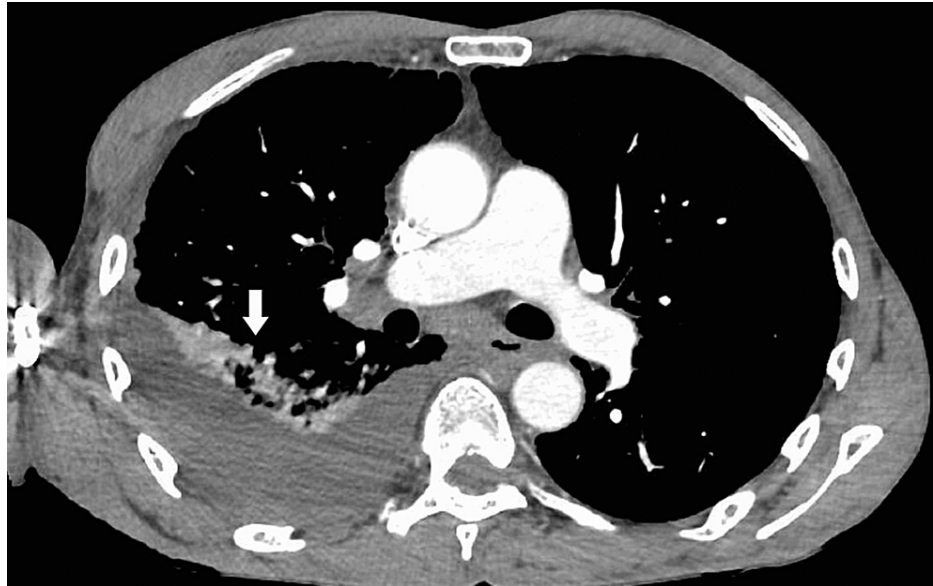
CT scan of the chest with contrast (axial view) showing right-sided pleural effusion
